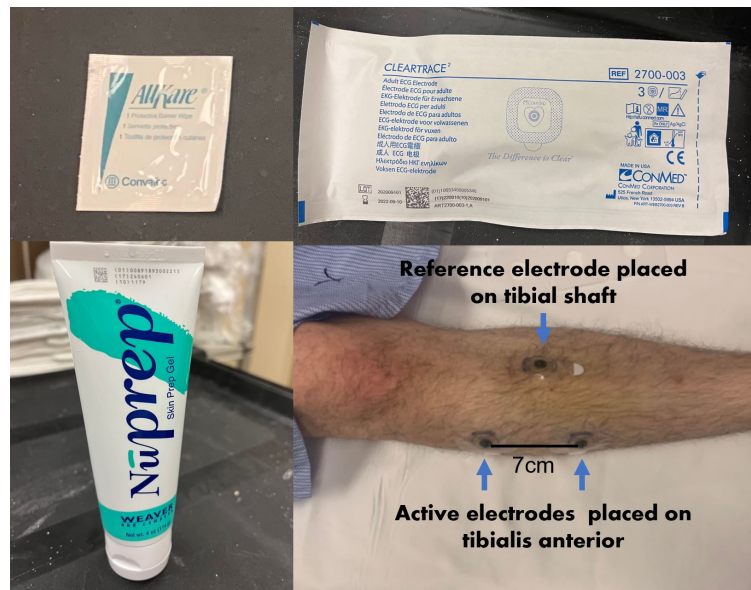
EMG preparation materials and set-up. Alcohol wipes, abrasive gel, carbon based MRI compatible MRI electrodes and electrode positioning on a sample participant.
